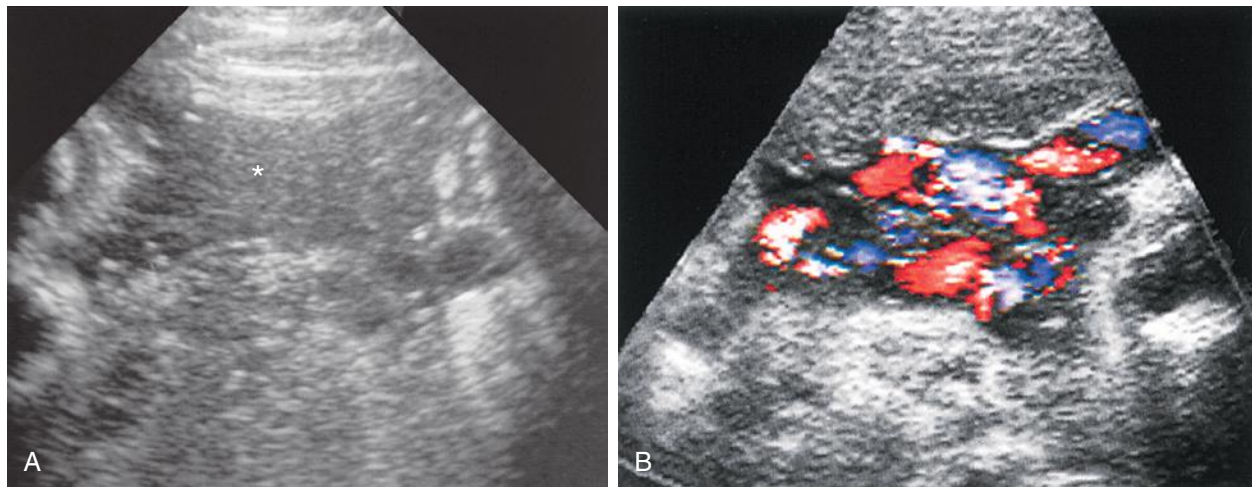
A, Apparent amniotic fluid pocket (*asterisk*) in a third trimester pregnancy. B, Color Doppler interrogation reveals that this pocket is entirely filled with umbilical cord.
